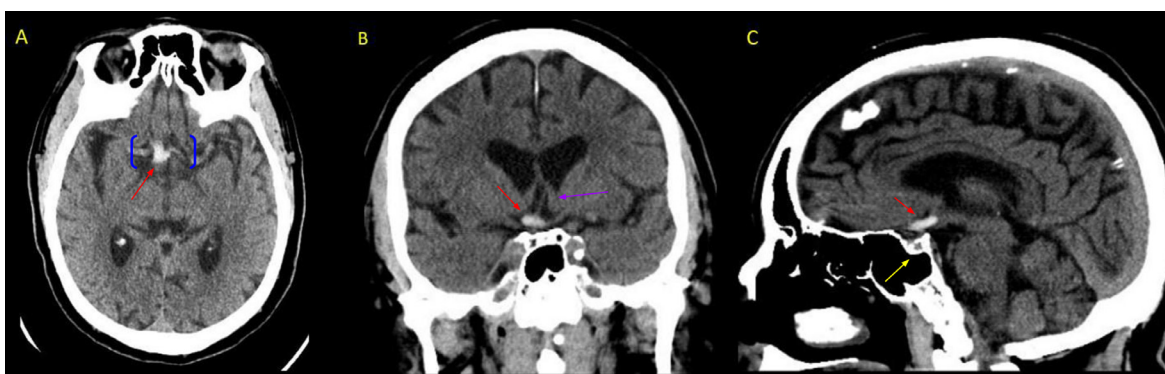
STAT CT head without contrast. CT of the head from an axial view (A), a coronal view (B), and a sagittal view (C). The red arrow indicates the silicone oil in all views, and is high density that can be seen in the right aspect of the optic chiasm as well as in the adjacent portions of the right optic nerve and optic tract. Without proper knowledge of patient history, the hyperintensity can be mistaken as a hemorrhage or an aneurysm. The blue brackets demonstrate the suprasellar space. The purple arrow demonstrates the anterior cerebral artery. The yellow arrow demonstrates the sella.
